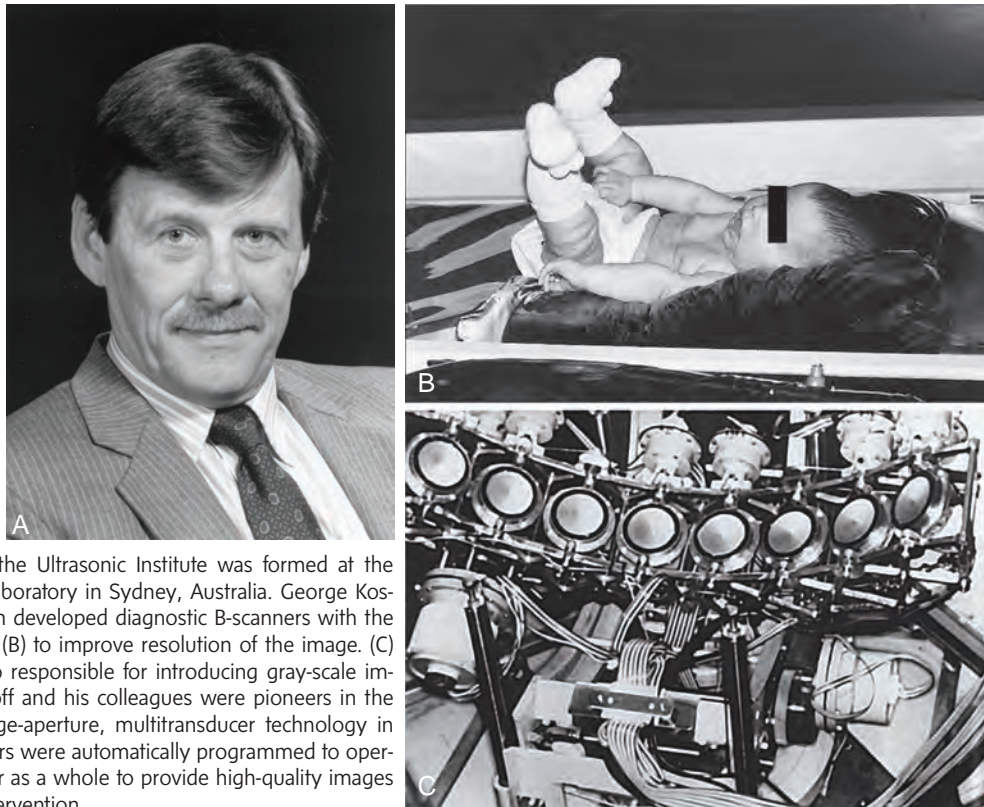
In 1959 the Ultrasonic Institute was formed at the National Acoustic Laboratory in Sydney, Australia. George Kossoff (A) and his team developed diagnostic B-scanners with the use of a water bath (B) to improve resolution of the image. (C) This group was also responsible for introducing gray-scale imaging in 1972. Kossoff and his colleagues were pioneers in the development of large-aperture, multitransducer technology in which the transducers were automatically programmed to operate independently or as a whole to provide high-quality images without operator intervention.
